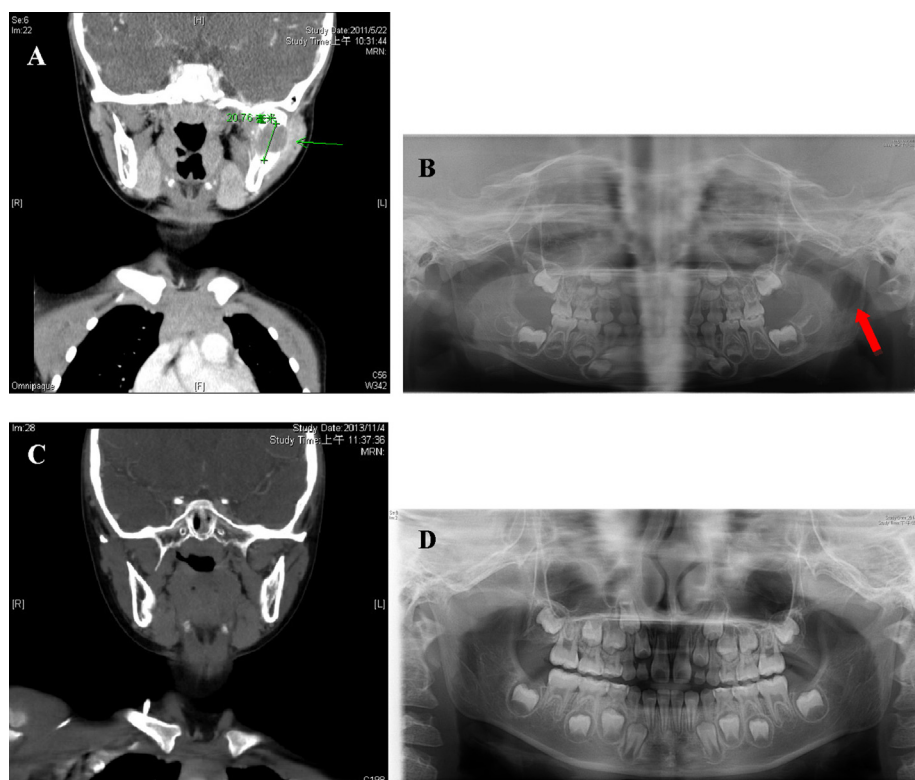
Head and neck computed tomography and dental panoramic radiography showing a radiolucent lesion in the left ascending ramus and condylar region of a pediatric patient (A and B) before and (C and D) after treatment.
